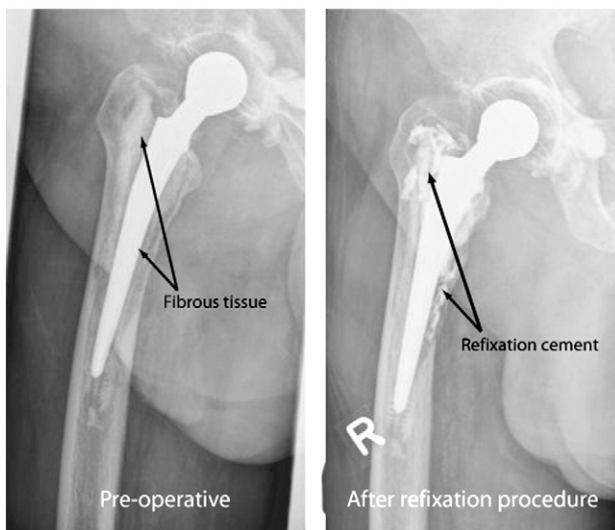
Example of radiographic results before and after cement injection.
